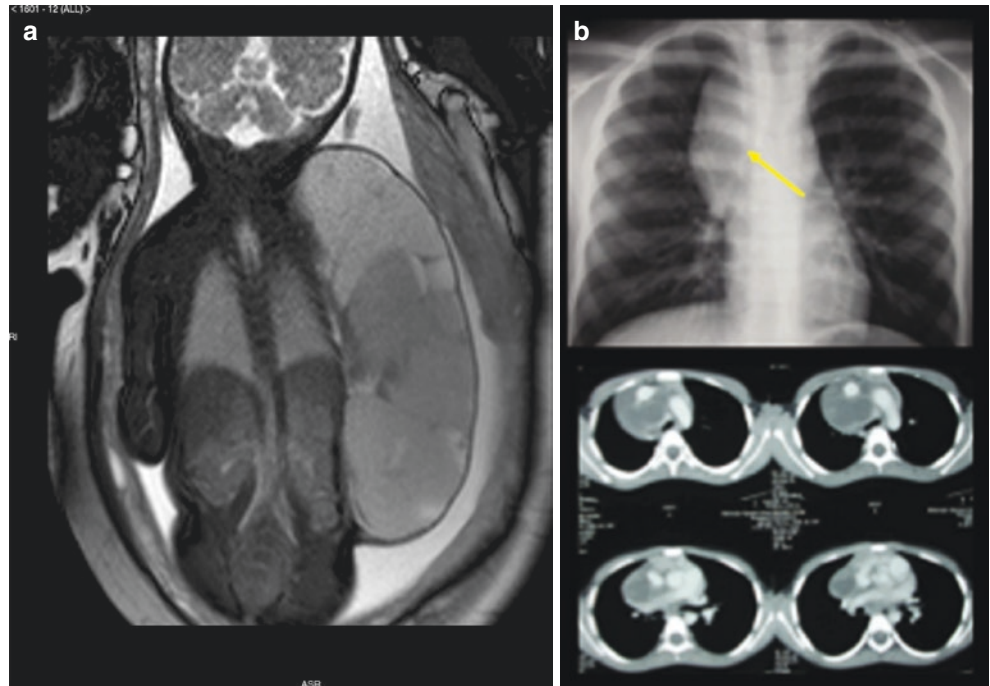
(a) Eventration of the left side of the diaphragm. (b) Chest X-ray of left sided eventration
